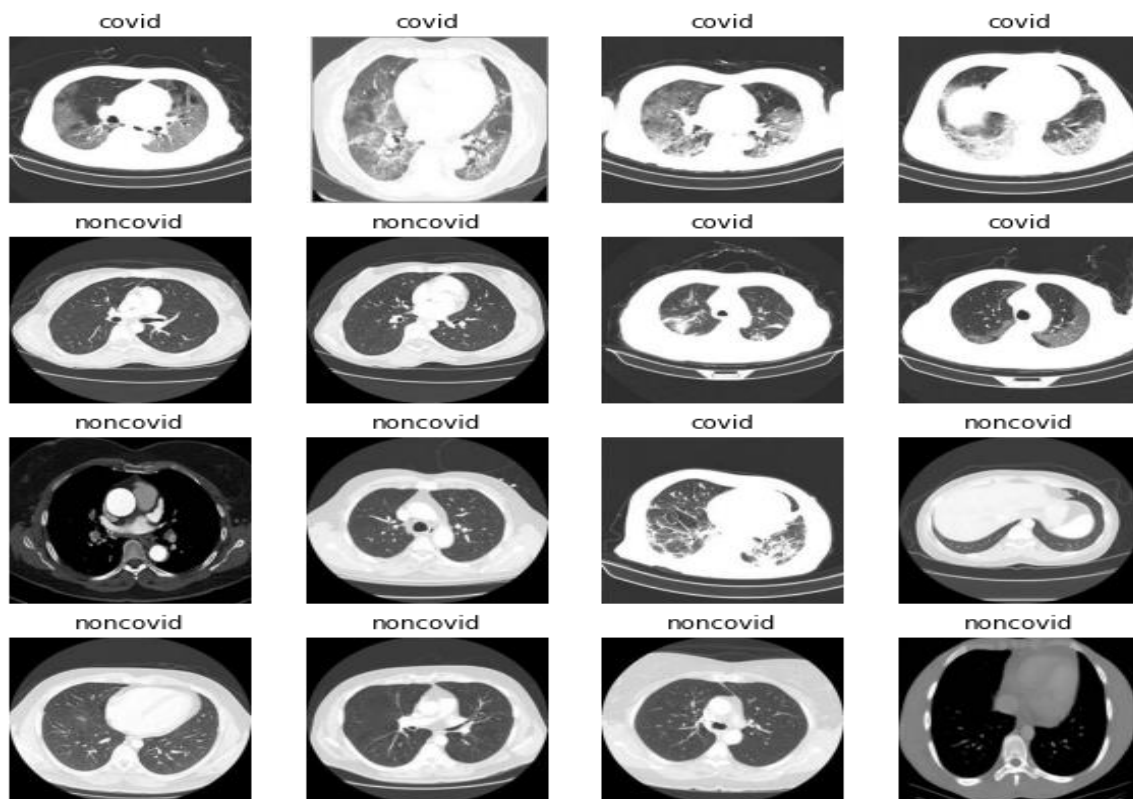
Sample CT scan Images from Database
